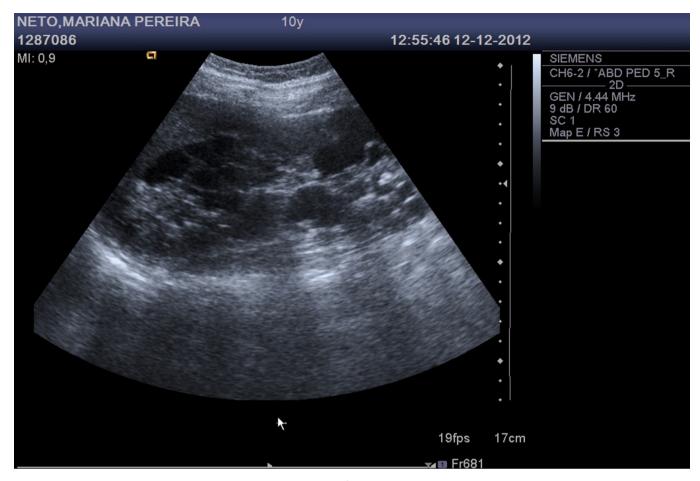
Renal ultrasonographic: enlarged kidneys with multiple cystic formations.
